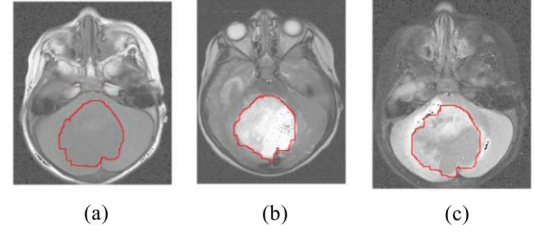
Example MRI slice for (a) T1; (b) T2; and (c) FLAIR modalities for patient #8. Tumors have been shown using boundary.
